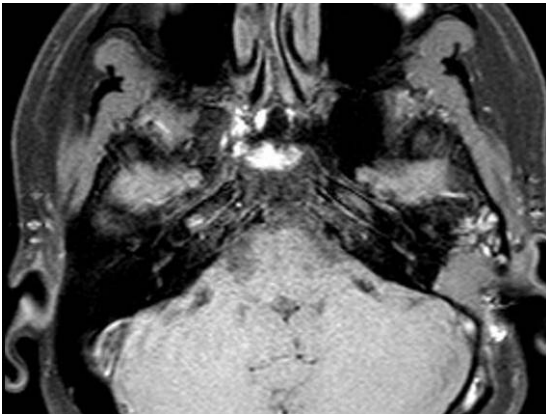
Case 1 trace of vestibular nerve on temporal MRI.
